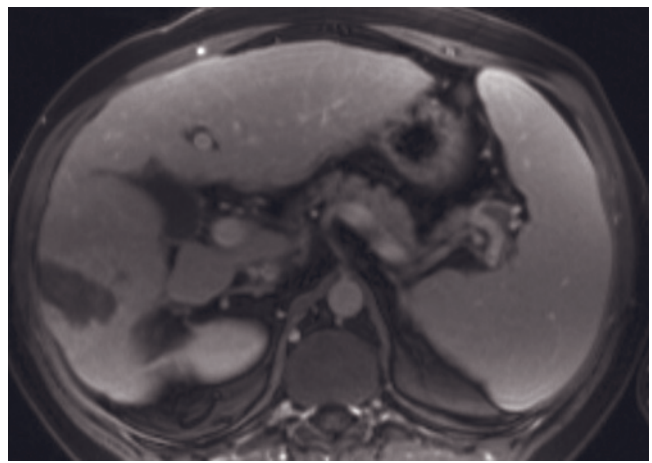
HCC before and after RF ablation—early changes. T2-weighted SS-ETSE (*a*, *e*), SGE (*b*, *f*), and immediate (*c*, *g*) and 90-s fat-suppressed (*d*, *h*) postgadolinium SGE images. Before RF ablation (*a*–*d*), a lesion is appreciated in the right hepatic lobe that shows mildly high signal intensity on T2-weighted image (*a*), mildly low signal intensity on T1-weighted image (*b*), and intense enhancement on early-phase image (*d*) that fades with capsule enhancement on late-phase image (*d*), consistent with an HCC. At 1 week after RF ablation (*e*–*h*), the ablated area demonstrates isointensity on T2-weighted image (*e*), high signal intensity on T1-weighted image (*f*), and lack of enhancement on early (*g*)– and late (*h*)–phase images. Surrounding the ablated area, there is
